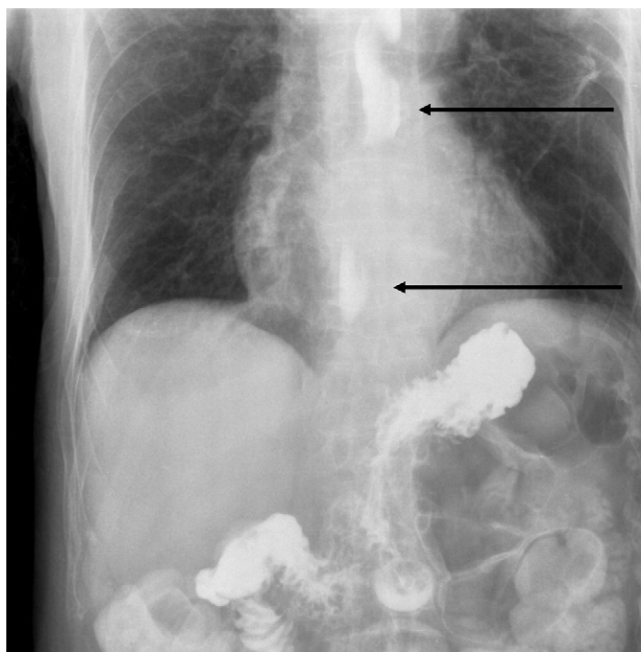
Upper GI series. X-ray of the abdomen and chest in a patient with a gastrostomy. Radiocontrast was injected into the stomach and quickly seen migrating upward through the entire esophagus (arrows). The patient had severe reflux esophagitis (Los Angeles grade D). (Figure courtesy Steven Fruitsmaak at http://en.wikipedia.org/wiki/File:Gastroesophageal_reflux_barium_X-ray.jpg).
